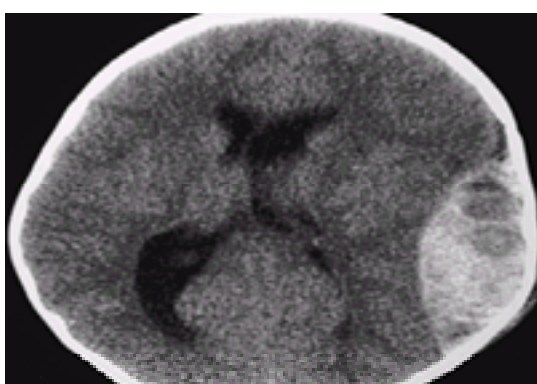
Epidural hematoma. This 11-month-old boy presented with progressive lethargy and vomiting after falling 2 feet off of a bed. Several hours after the injury, he became unresponsive with dilated, nonreactive pupils. This head computed tomography (CT) scan shows a large epidural hematoma, with intermingled hypodense areas representing active bleeding. Note also the midline shift and the compression of the ipsilateral ventricle. After an emergency craniotomy, the patient made a full recovery.
